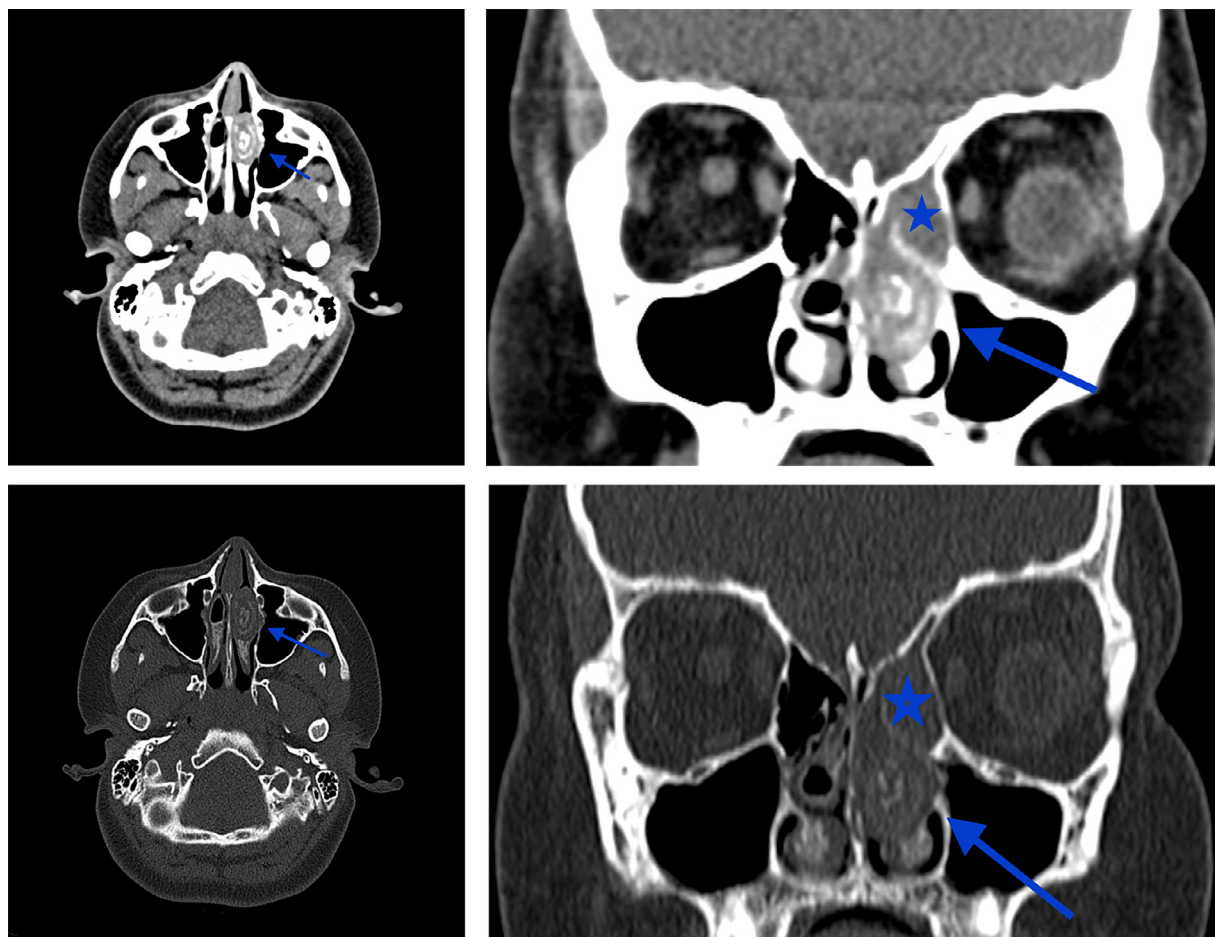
CT axial and coronal plane, soft tissue (A-B) and bony (C-D) windows. On the left side enlarged concha bullosa (arrow) containing hyperdense material and calcifications was found. Note the mucosal and bony wall thickening with rarefaction of the latter. Ethmoidal air cells opacification was associated (star).
